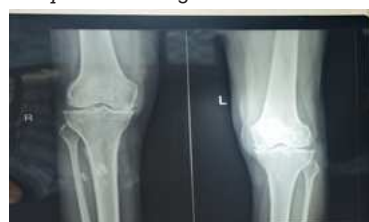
PRE -OP X-RAY Bilateral medial compartment osteoarthritis
